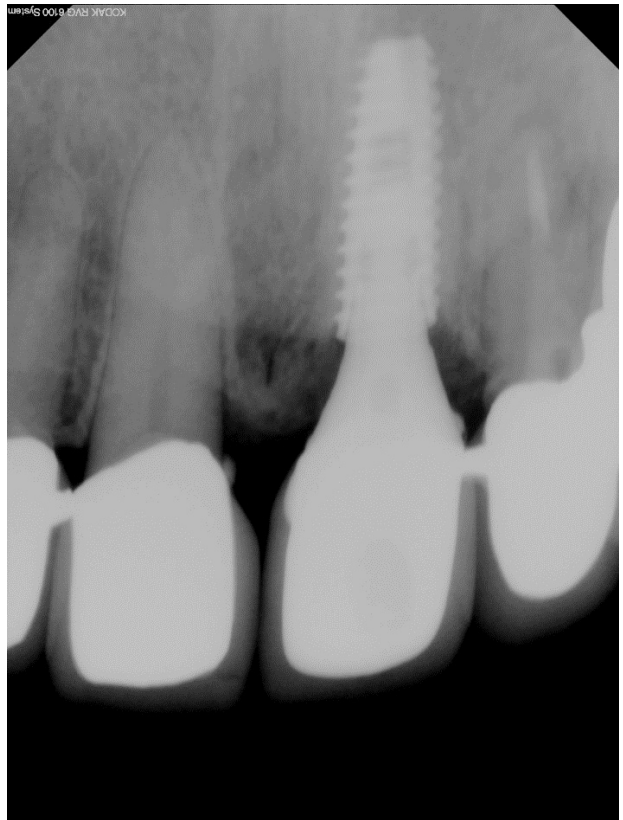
Periapical radiograph after definitive prosthesis was delivered.
